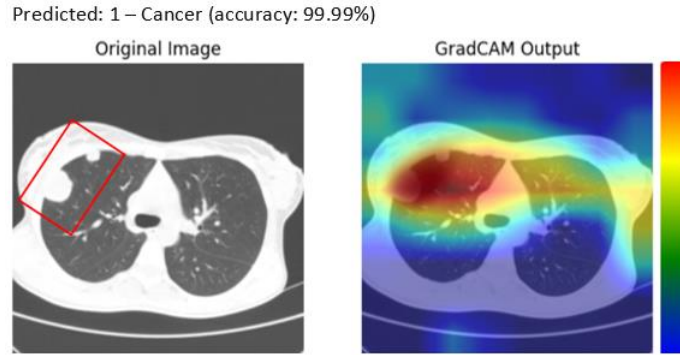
GradCAM result of CT image with a model of DenseNet169
